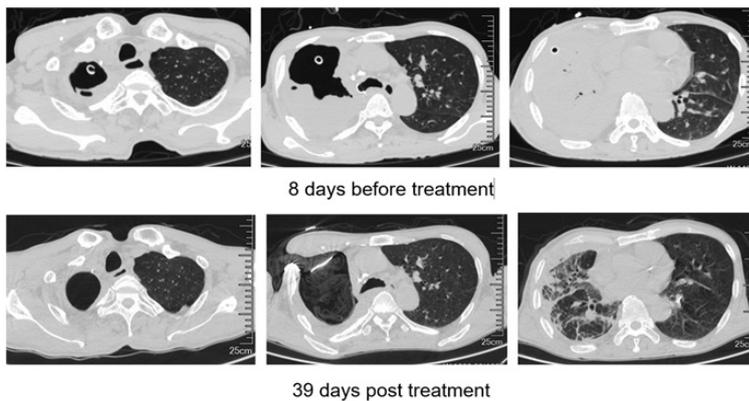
Patient clinical data during phage therapy. (D). The patient's chest CT scans 8 days before phage therapy and on day 39 after phage therapy.
